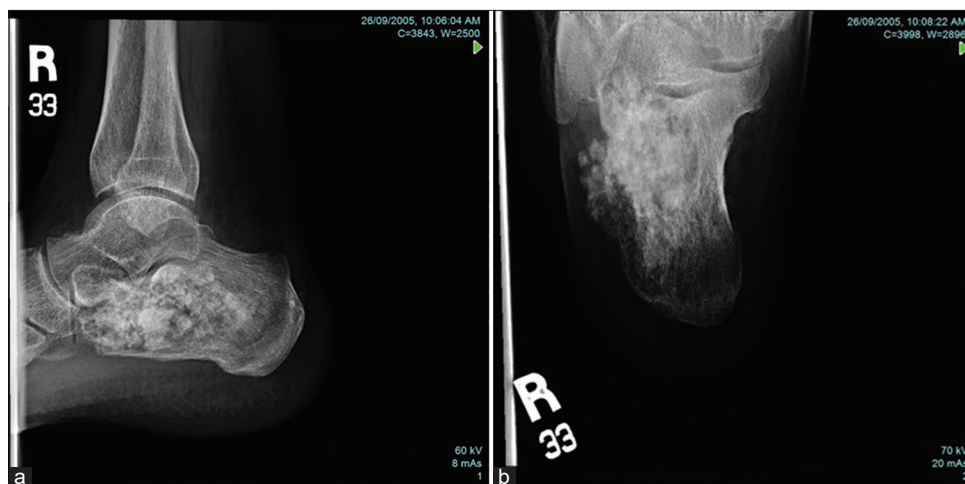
(a) Plain radiograph lateral view showing an osteoblastic calcaneal lesion and (b) axial view of calcaneus showing lateral extraosseous extension.
